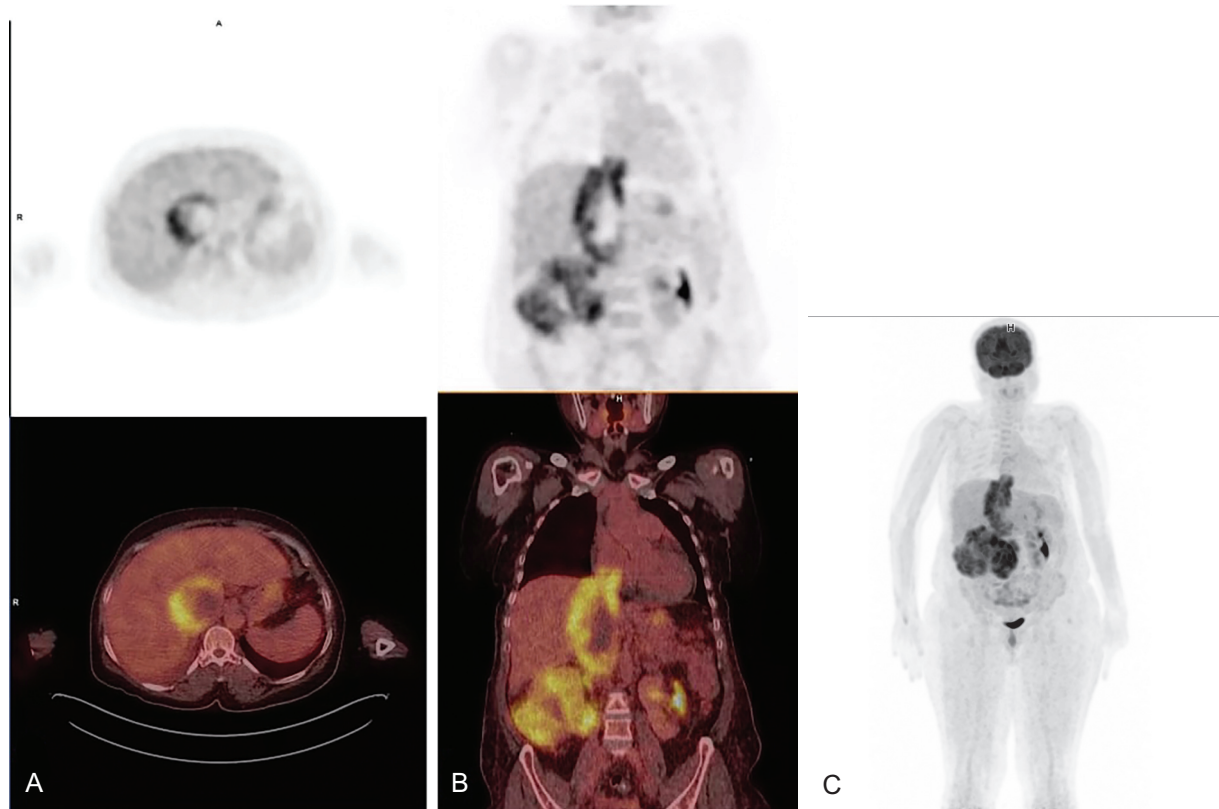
Positron emission tomography/computed tomography (PET/CT) axial view (A) demonstrates hypermetabolic circumferential wall thickening within the inferior vena cava (IVC). PET and PET/CT coronal view (B) images demonstrate heterogeneous intensely hypermetabolic huge mass with areas of central necrosis replacing the right kidney invading the IVC and reaching the right atrium. Maximum intensity projection (C) also shows the extension of tumor thrombus from the right kidney to the right atrium.
